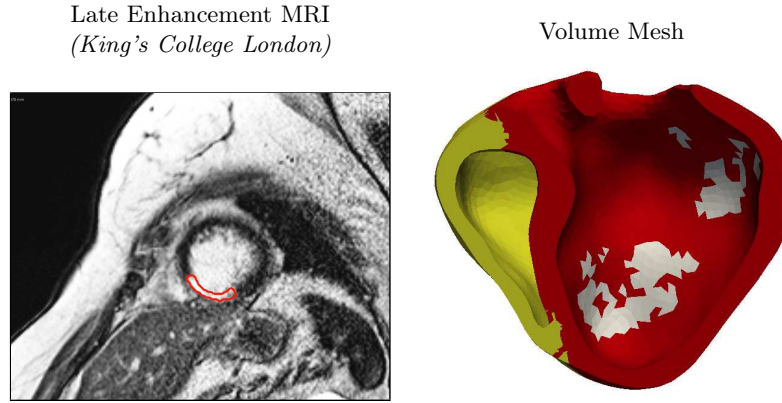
Left panel:* Late enhancement MRI showing a myocardium scar *in red* in a patient with heart failure. The scar is manually delineated. *Right panel:* The scar is automatically mapped onto the patient-specific volume mesh: left ventricle (*in red*), right ventricle (*in yellow*), scar (*in white*).
